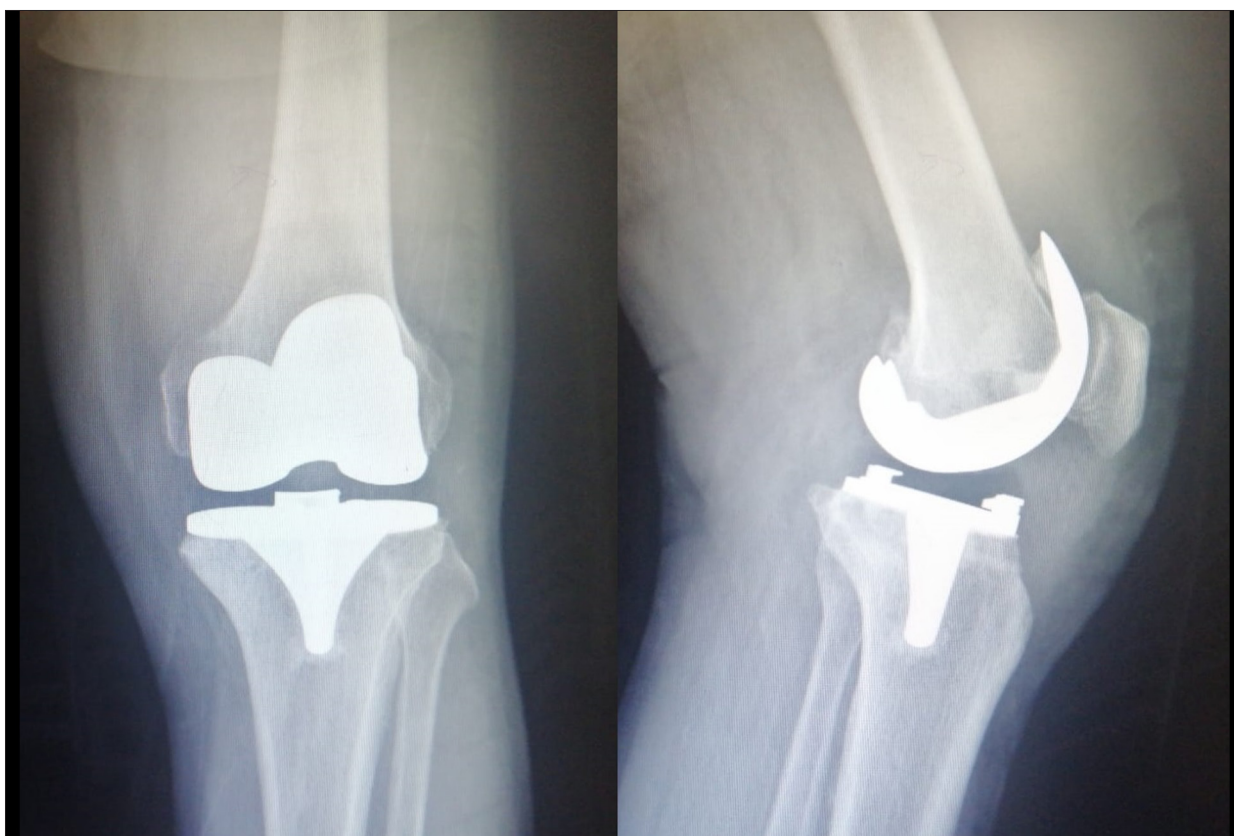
X-ray (post-op 2 years).
